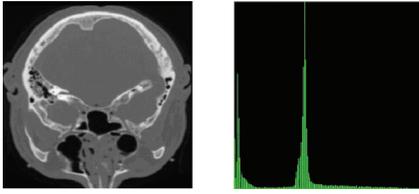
CT scan and intensity histogram.
